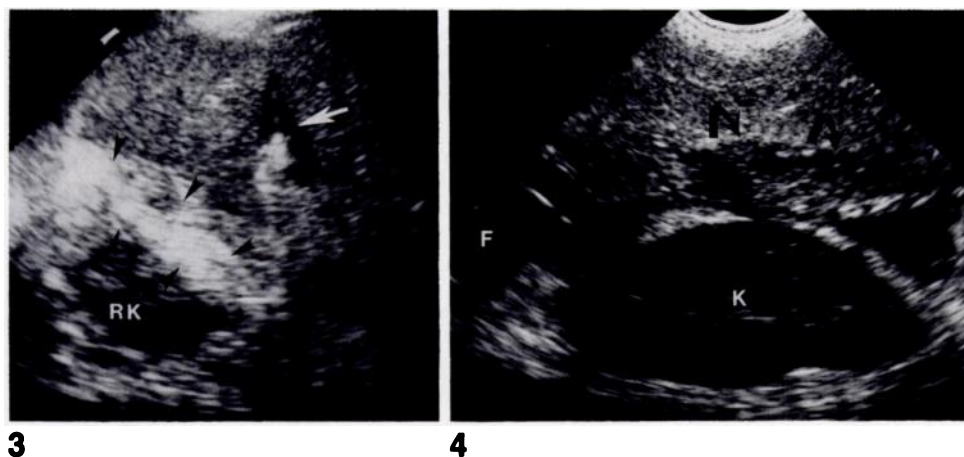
Transverse sonogram of patient with transplanted left-lobe allograft shows a ring of echogenic material (arrowheads) along cut edge. Note fluid along falciform ligament (arrow). RK = right kidney.
